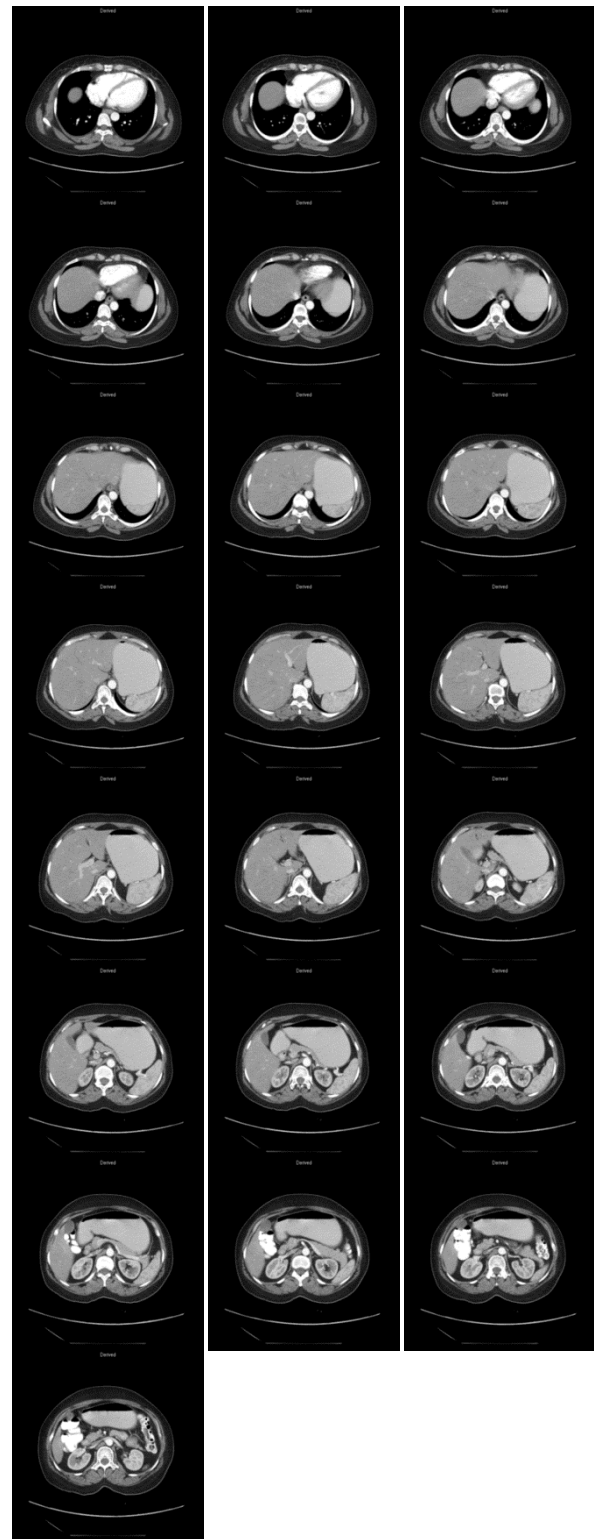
Original volume of CT abdomen images
